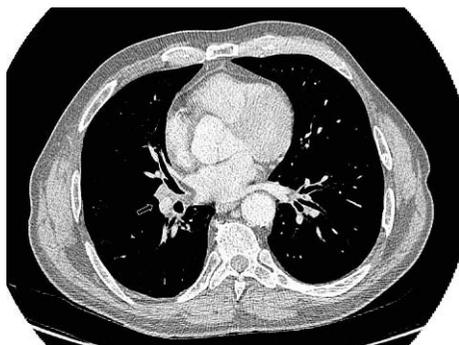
Preoperative computed tomography scan showing a lung nodule of heterogeneous density with a diameter of 3.8 cm in the right lower lobe; the nodule is seen to be touching the pleura.
